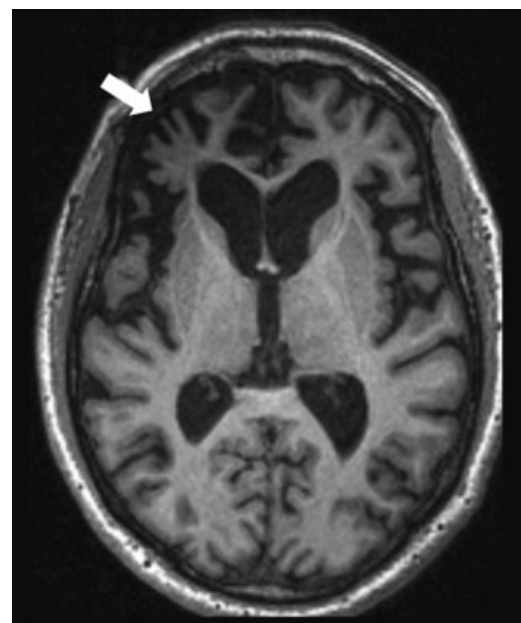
Axial T1-weighted magnetic resonance imaging (MRI) in a 62-year-old patient with behavioral variant frontotemporal dementia showing profound right > left frontal lobe (arrows) atrophy. Orientation is radiological.
